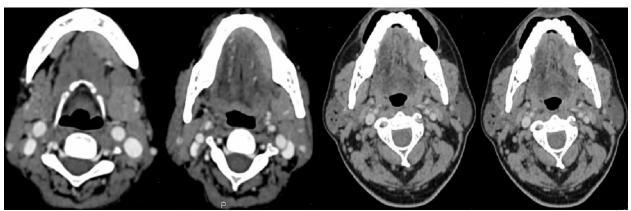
Contrast enhanced CT of face and neck demonstrates enhancing soft tissue mass along left anterolateral aspect of tongue. It does not cross the midline and is limited to intrinsic muscle of tongue. Multiple bilateral cervical lymph nodes also noted
